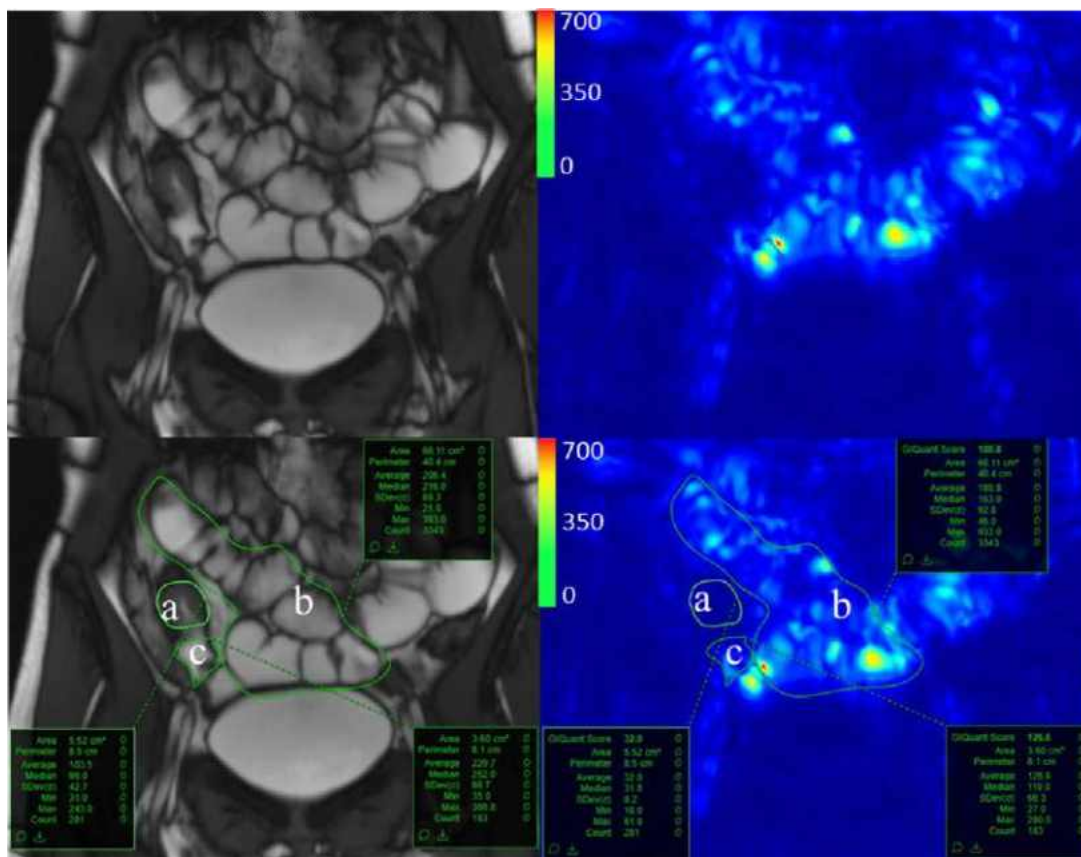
Quantified small bowel motility in a patient with terminal ileal CD. Anatomic reference True-FISP (fast imaging with steady-state precession; Siemens) MR images are on the left, with the corresponding color motility maps at the same location on the right. The bottom row of images shows regions of interest (green lines) drawn over three anatomic locations, as follows: over the terminal ileal stricture (*a*), over the uninvolved ileum (*b*), and just proximal to the stricture segment (*c*). The motility scores, derived from the GIQuant system, reveal a score of 32 at the stricture, in contrast to the uninvolved loop (score, 181), and just proximal to the stricture (score 127).
